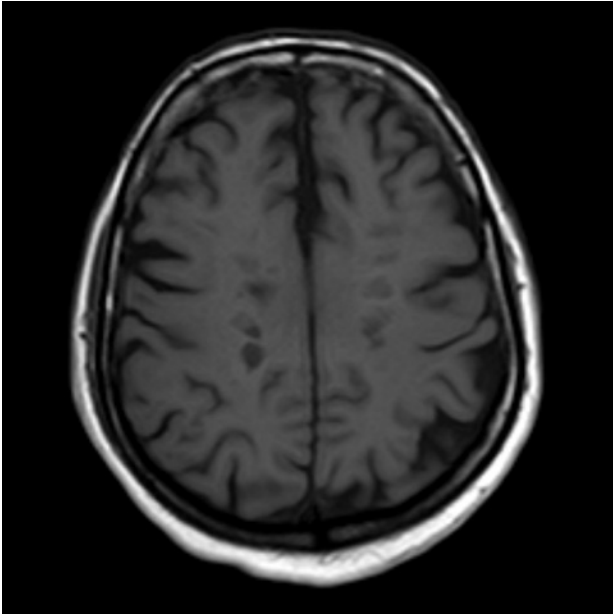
Axial T1-weighted MR image showing “black holes” in the brain of a patient with MS. Image courtesy of Ahmed Abd Rabou, MD, Radiopaedia.org, rID: 35195.
